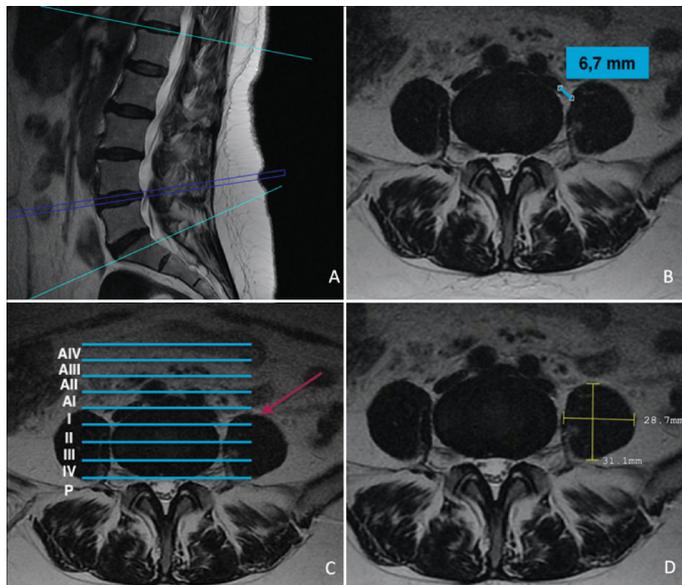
T2-weighted lumbar MRI of a 57-year-old woman. A. Sagittal showing the L4/L5 disc level where the measurements are made in the axial slices. B. Oblique corridor L4/L5 Grade 1. C. Left psoas height: I according to the modified Moro classification. D. Measurement of the psoas area at the L4/L5 level. Although this patient does not have “high psoas”, the oblique approach is technically difficult because she has <10 mm of the oblique corridor.
